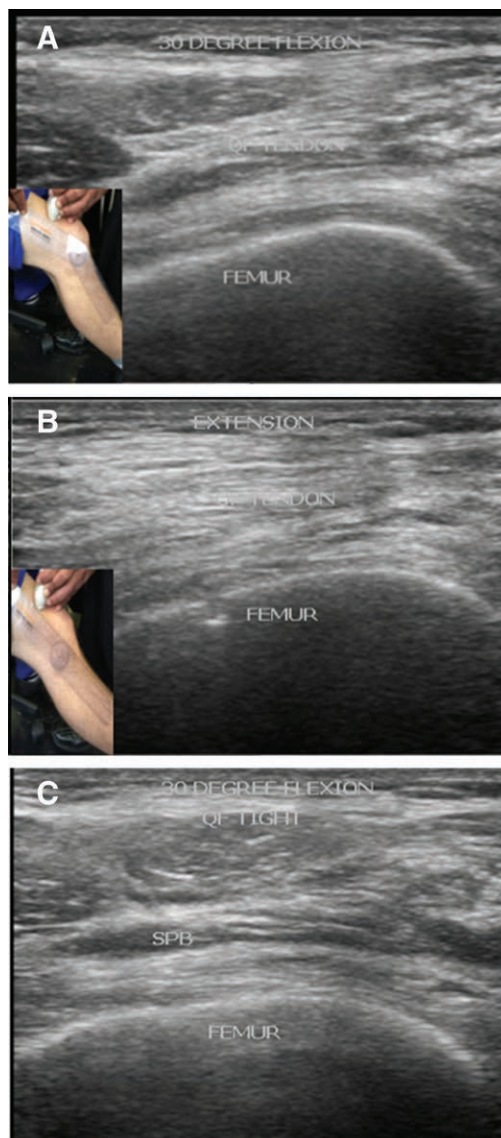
(A) Ultrasound of the knee in 30° flexion. (B) Ultrasound of the knee in extension. (C) Ultrasound image of the knee in 30° flexion with contraction of the quadriceps. SPB = suprapatellar bursa; QF = quadriceps femoris.
